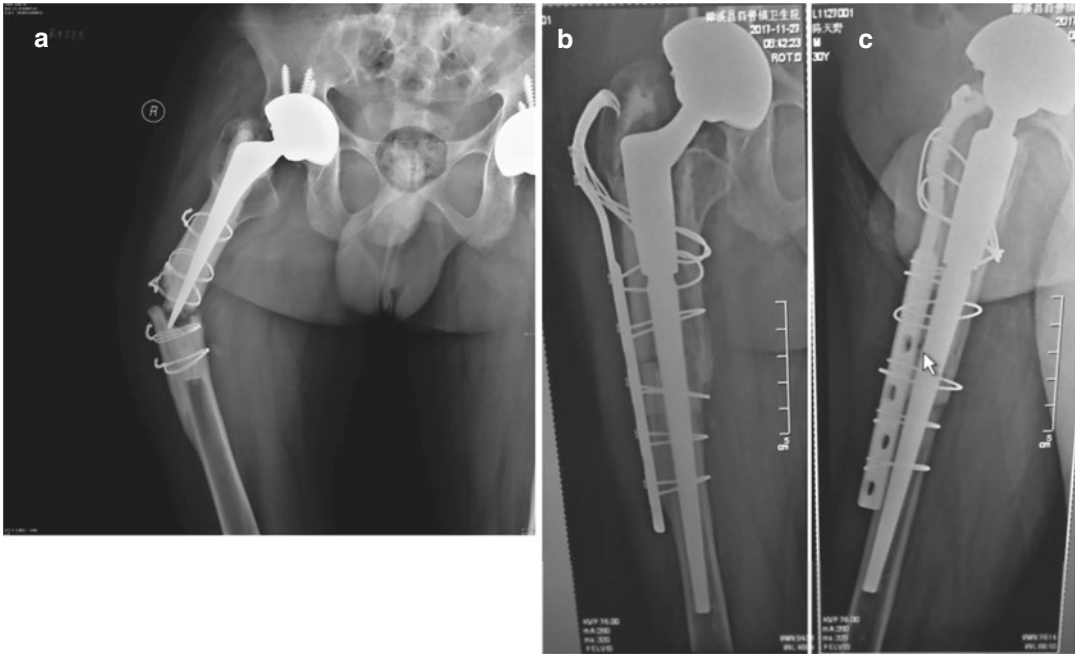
Radiographs of short and transverse periprosthetic femoral fracture type B1. (a) Preoperative image. (b) Postoperative image after treatment with revision
